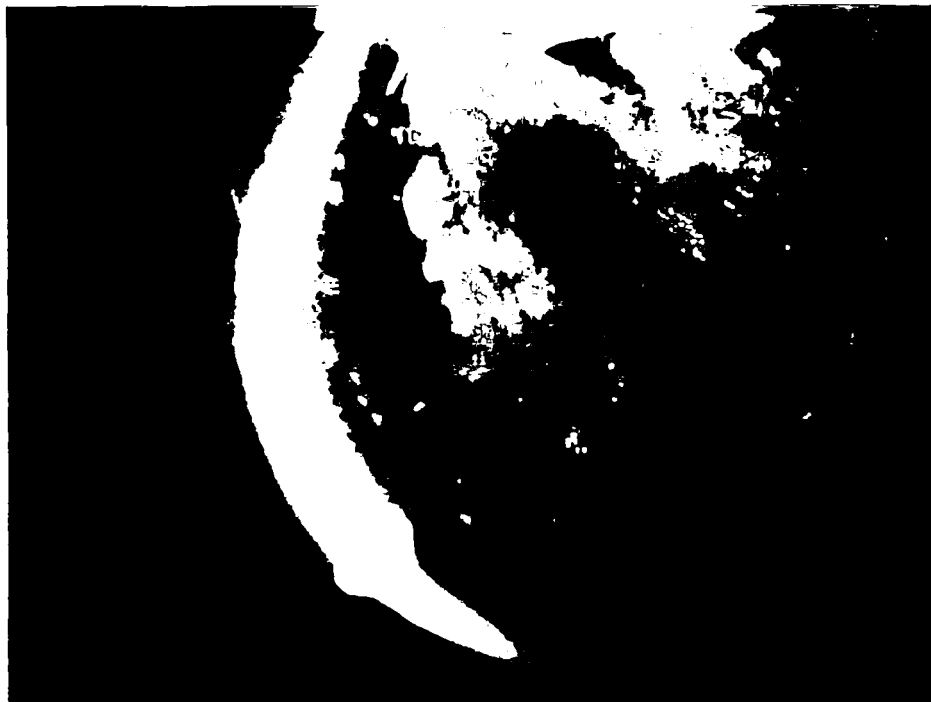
Ultrasound image of 9 cm diameter pedunculated vaginal mass (upper, arrow) attached to the cervix. Endoscopic view of vaginal mass via speculum examination.
